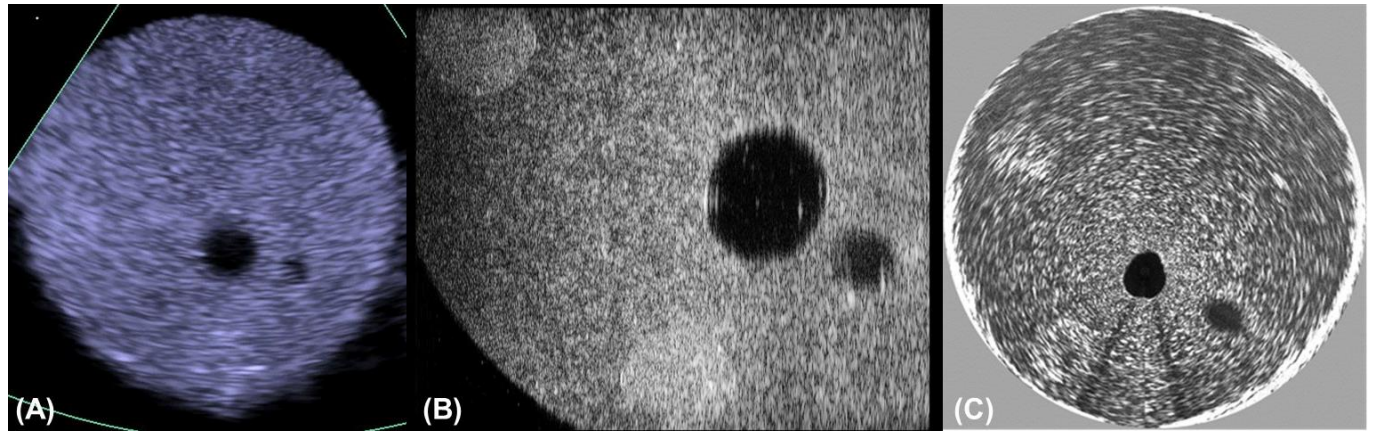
Comparison of transurethral probe with commercial transducers. Images acquired with (A) an 8 MHz intravenous (IVUS) ultrasound probe, (B) a 20 MHz hand held transducer, and (C) the transurethral ultrasound probe developed in this project. The transurethral probe has higher image contrast than the IVUS probe and a larger field of view than the hand held transducers.
